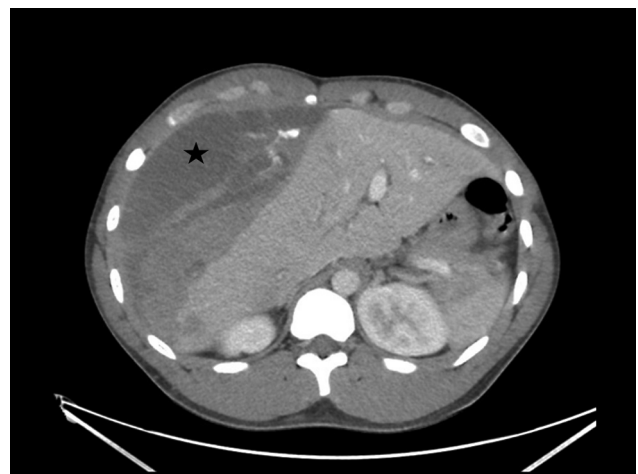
An initial computed tomography (CT) scan of the abdomen showing a large right lobe subcapsular hepatic hematoma (indicated by the black star). An extensive mass effect was also noted, and hence an underlying mass lesion could not be excluded on the basis of this study.
